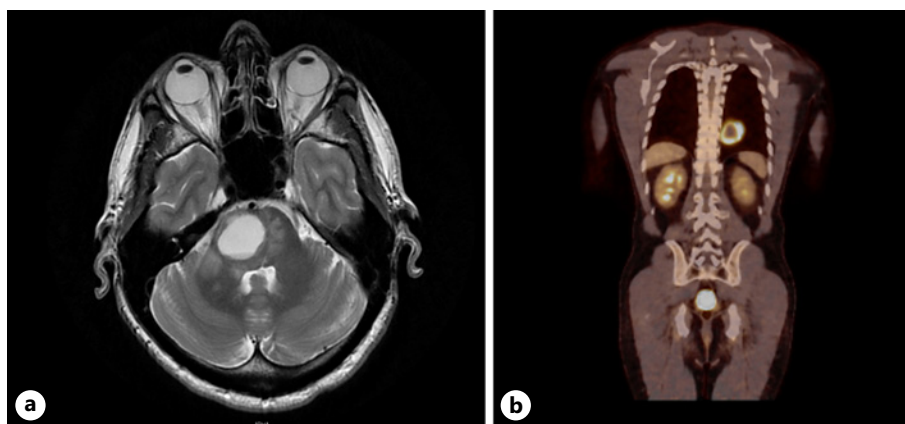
Radiological evidence of distant metastasis on MRI brain demonstrating right pontine lesion (a), and PET-CT scan demonstrating PET-avid left-sided pulmonary lesion (b). PET, positron emission tomography; MRI, magnetic resonance imaging.
